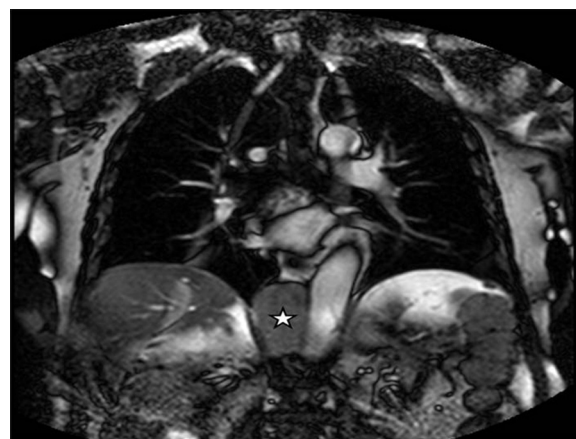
Coronal MRI plane showing a 6-cm thoracoabdominal tumor situated in the aortic hiatus (star) that extended to the retroperitoneum. On the sides of the lesion, there is a close relationship with the thoracic aorta and diaphragm.
